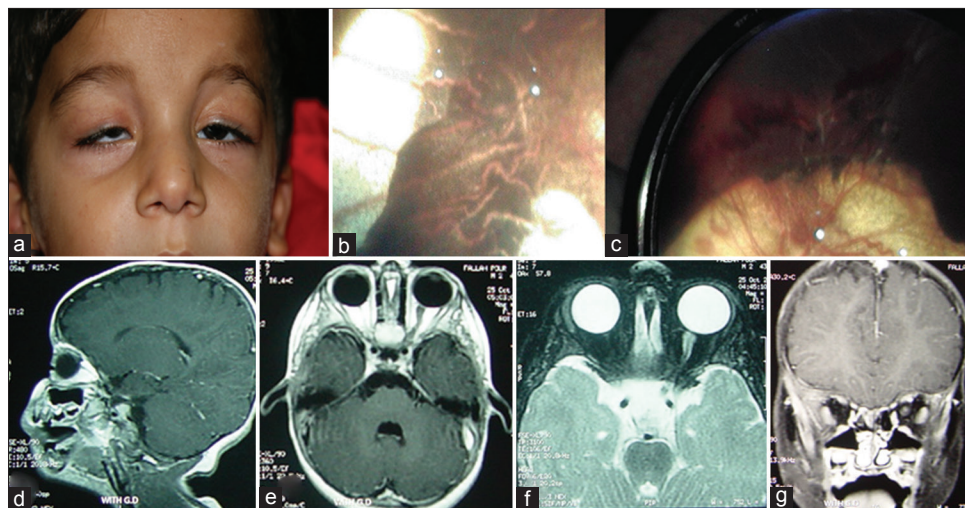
Case 1 – (a) bilateral ptosis, microphthalmia and strabismus in the right eye; (b) fundus photograph of the right eye shows a large chorioretinal coloboma and no retinal vessels and optic nerve head; (c) the superotemporal border of coloboma in the same eye shows a vascular tuft originating from the choroidal vessels. The left eye had normal fundus. (d-g) MRI shows a narrow stalk representing the presumed right optic nerve in the orbit but no other central nervous system anomaly is present. MRI, magnetic resonance imaging
